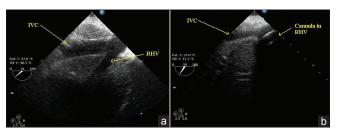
(a) Transesophageal echocardiographic image showing inferior vena cava and right hepatic vein before cannulation. (b) Malpositioning of the cannula in the right hepatic vein
